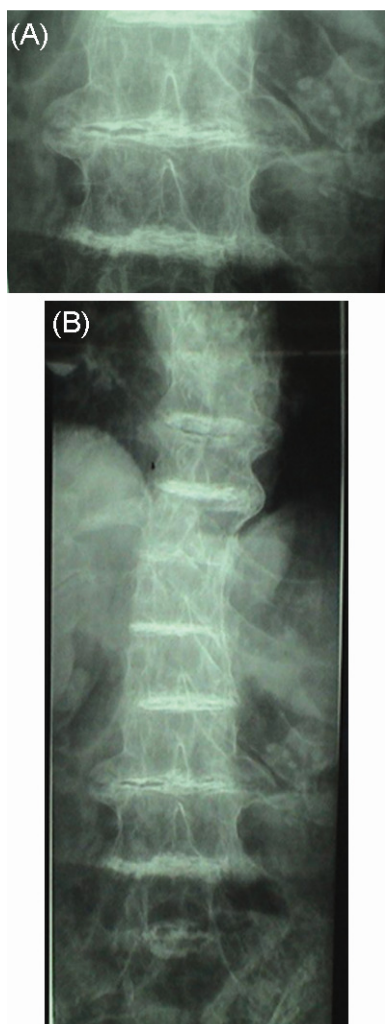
Radiographies of (A) dorso-lumbar and (B) dorso-lumbar-cervical spine showing a narrowing of joint spaces, calcifications of the intervertebral discs and porotic vertebral bodies
